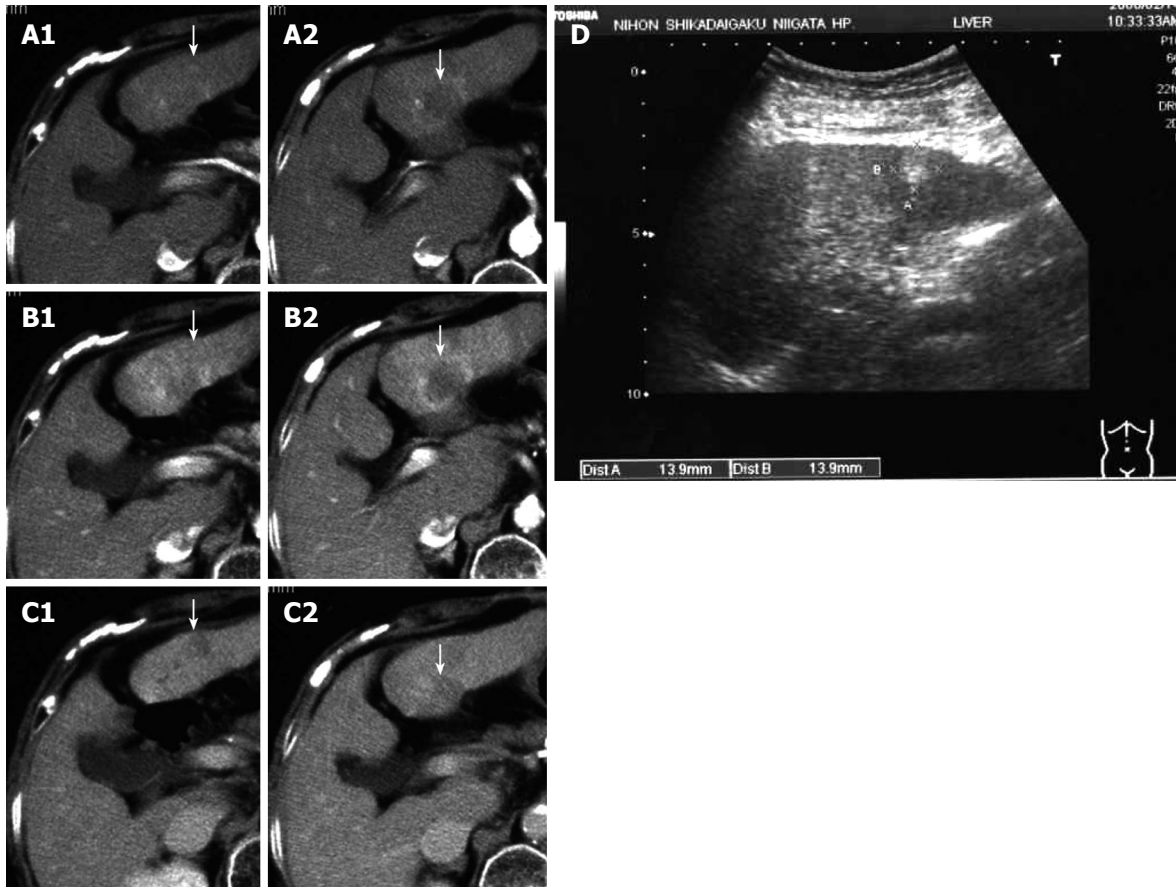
Dynamic computed tomography performed 12 mo after the first operation. The tumor on the ventral side of S3 appears to be a classic hepatocellular carcinoma and that on the dorsal side of S3 appears to be increased to ~3 cm in diameter. Typical findings including enhancement of the peripheral portion of the tumor in the early (A1) and parenchymal (B2) phases, and the slight and gradual enhancement of the internal portion in the delayed phase were observed (C2). Arrows indicate the tumors (A1, A2 arterial phase; B1, B2 parenchymal phase; C1, C2 delayed phase). Subcutaneous ultrasonography performed 12 mo after the first operation (D); The tumor on the ventral side of S3 is represented by a hyperechoic mass, 14 mm in diameter, a finding characteristic of hepatocellular carcinoma rich in fat. The tumor on the dorsal side of S3 is also represented by a hyperechoic lesion, ~30 mm in diameter, with irregular and unclear margins. Arrows indicate the tumors (D).
